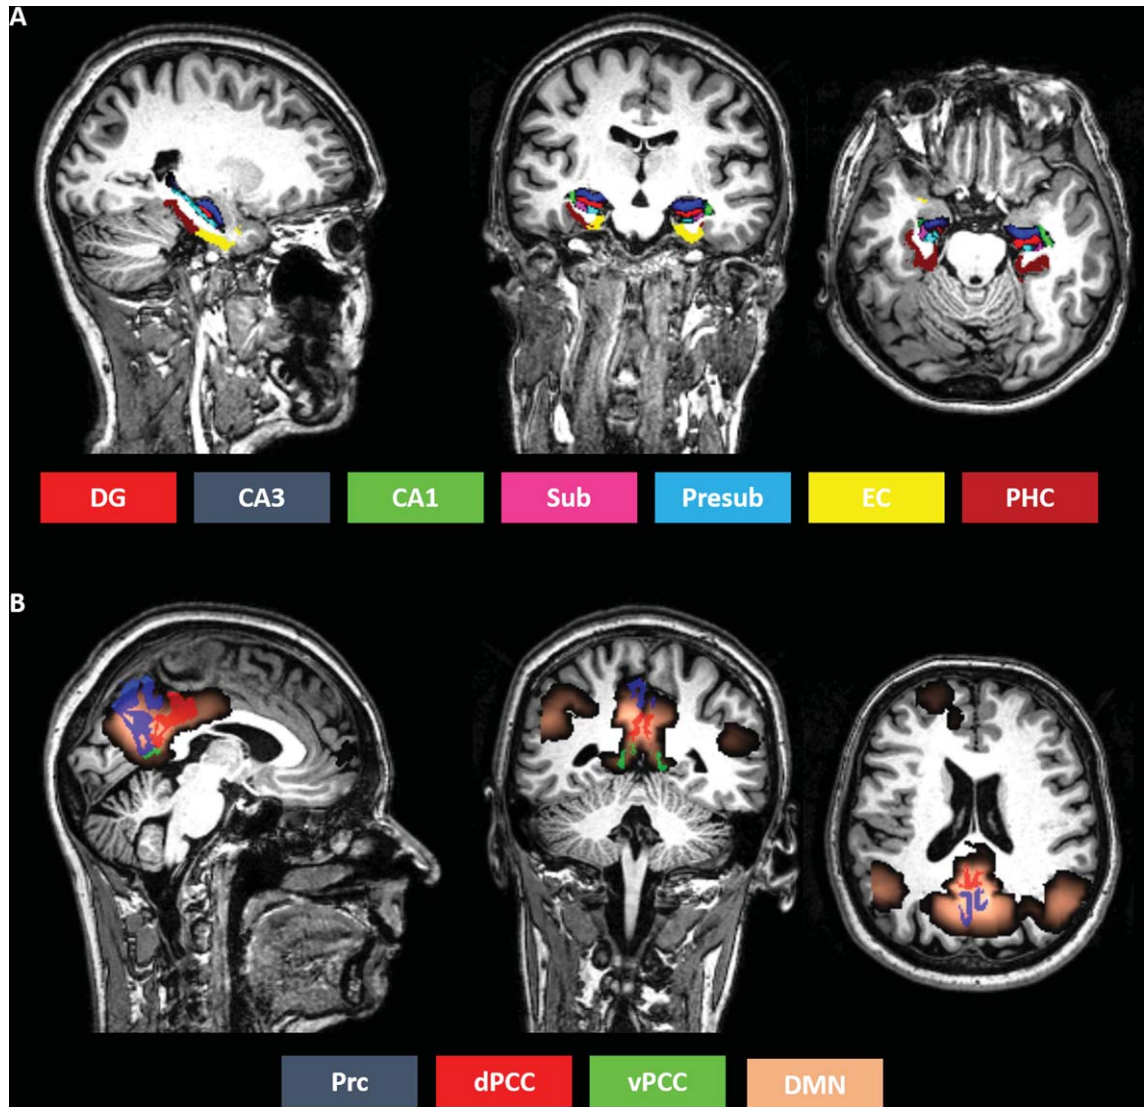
Parcellation of medial-temporal lobe and medial-parietal regions-of-interest. FreeSurfer software was used to parcellate each single subject's structural MRI data in medial-temporal lobe subregions (A) and medial-parietal regions overlapping with medial-parietal portions of the default mode network (B). The segmented regions constitute the regions-of-interest of the current study. CA, cornu ammonis; DG, dentate gyrus; DMN, default mode network; dPCC, dorsal posterior cingulate cortex; EC, entorhinal cortex; PHC, parahippocampal cortex; Prc, precuneus; Presub, presubiculum; Sub, subiculum; vPCC, ventral PCC.
